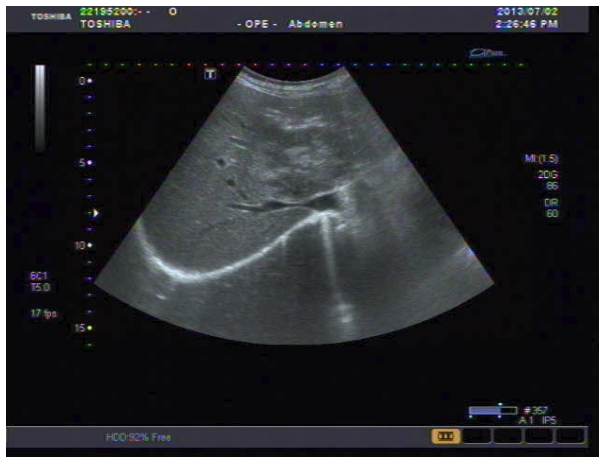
Ultrasonography showing irregular, ill-defined, mixed echoic liver masses around the hilum
